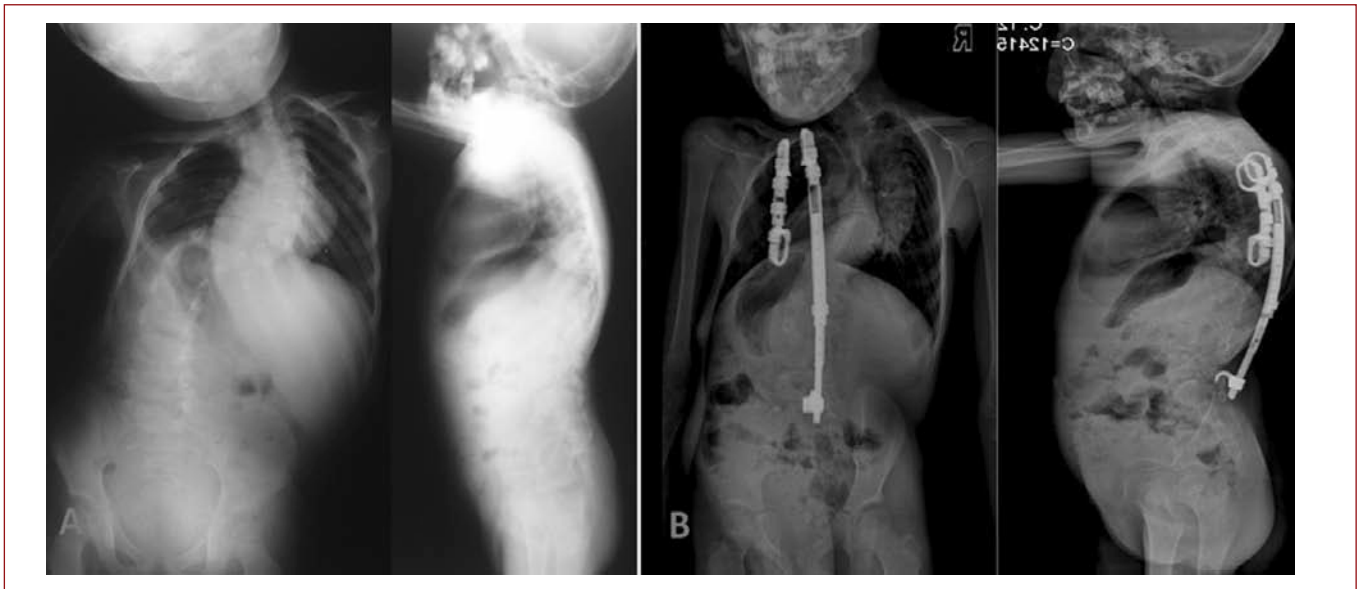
a. Preoperative posterior-anterior and lateral radiographs, b. Posterior-anterior and lateral radiographs after the follow-up period.
